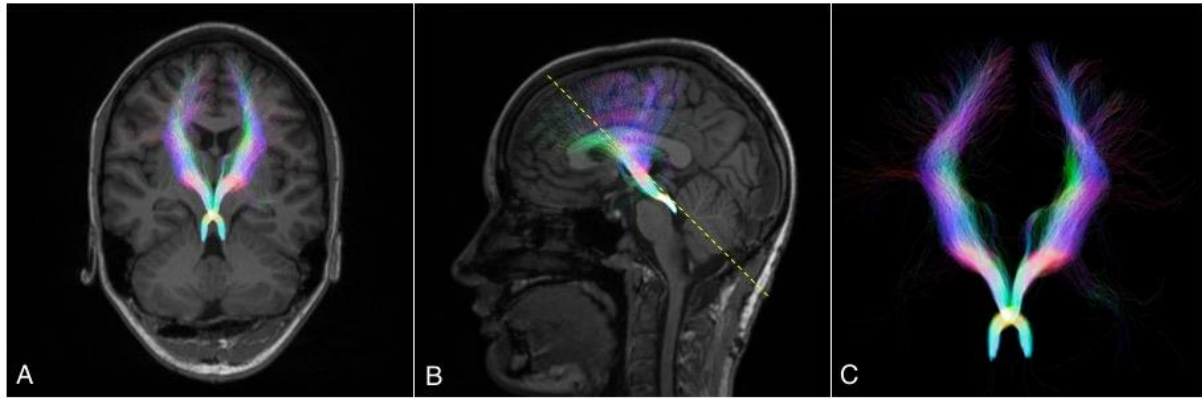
Probabilistic tractography streamline reconstructions of both DRTC tracts in a patient who recovered well after exophytic brainstem tumour debulking. A, bilateral 3-dimensional DRTC tract streamlines overlaid on a single T1-weighted slice in axis as per dotted yellow line in B. Note the decussation of both DRTC streamlines and their passage through the thalami towards widespread areas of cerebral cortex. B, bilateral 3-dimensional DRTC tract streamlines overlaid on a single T1-weighted sagittal slice. The majority of streamlines terminate in areas of frontal cortex. C, bilateral 3-dimensional DRTC streamlines viewed in isolation in coronal projection, depicted in standard radiological convention and with directional colour encoding as described in Figure 4C. Images acquired and processed at our institution using MRtrix 3.0[84].
